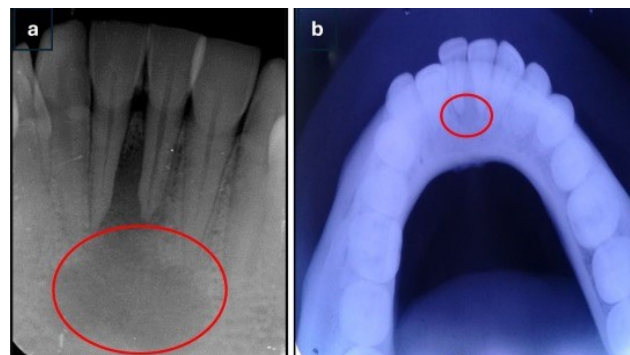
IOPAR and Occlusal radiographs of mandible showing radiolucency measuring approximately 1.5x2 cm extending from distal aspect of 31 to distal aspect of 41.
